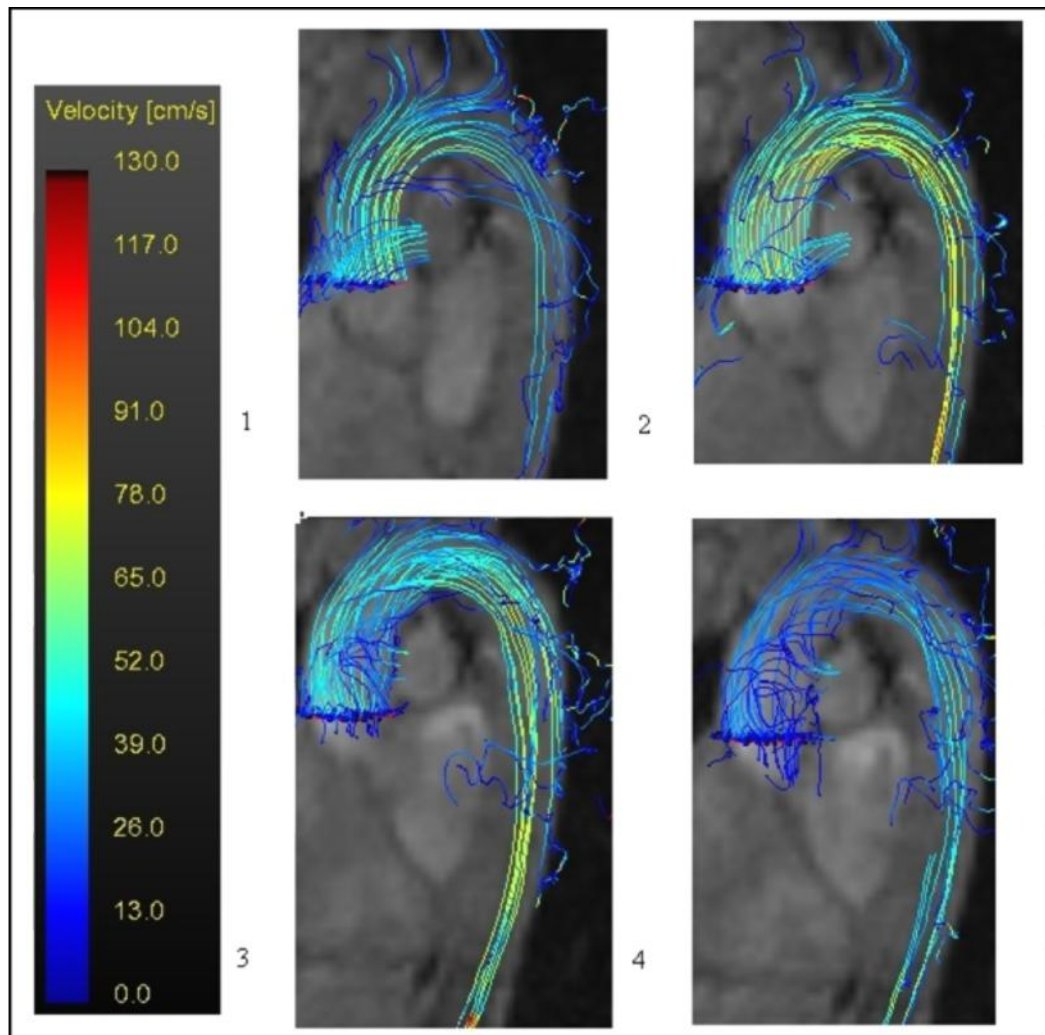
MRI flow patterns
